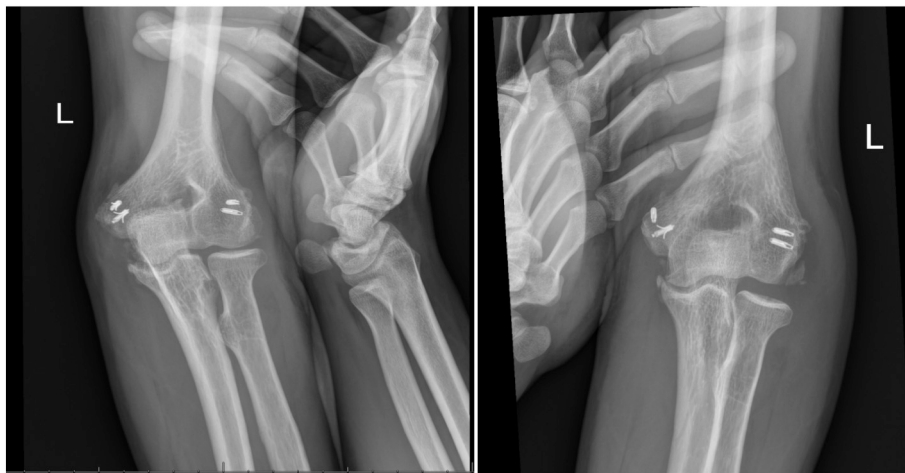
Stress radiographs 11 weeks after repair showing residual varus opening.
